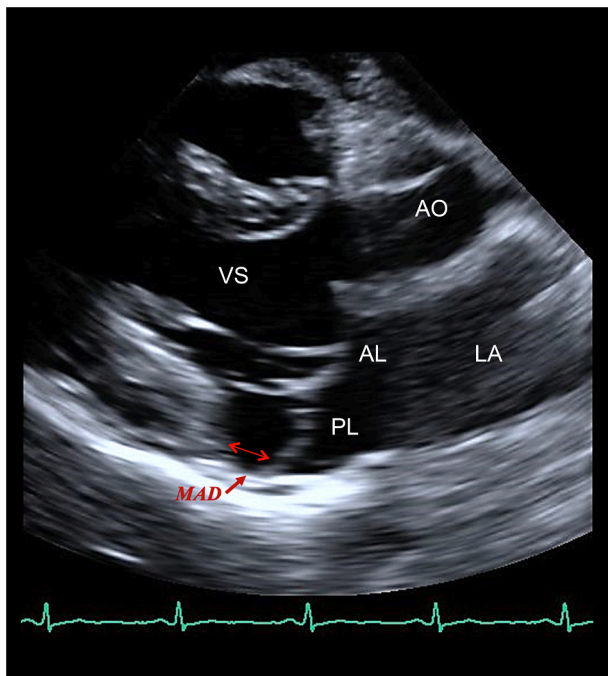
In the parasternal long axis view the presence of mitral annular disjunction (MAD) is appreciated (red arrow) as a detachment between the posterior myocardium and the posterior mitral annulus. The two mitral leaflets are visible. AL: anterior leaflet; AO: aortic root; LA: left atrium; LV: left ventricle; PL: posterior leaflet.
